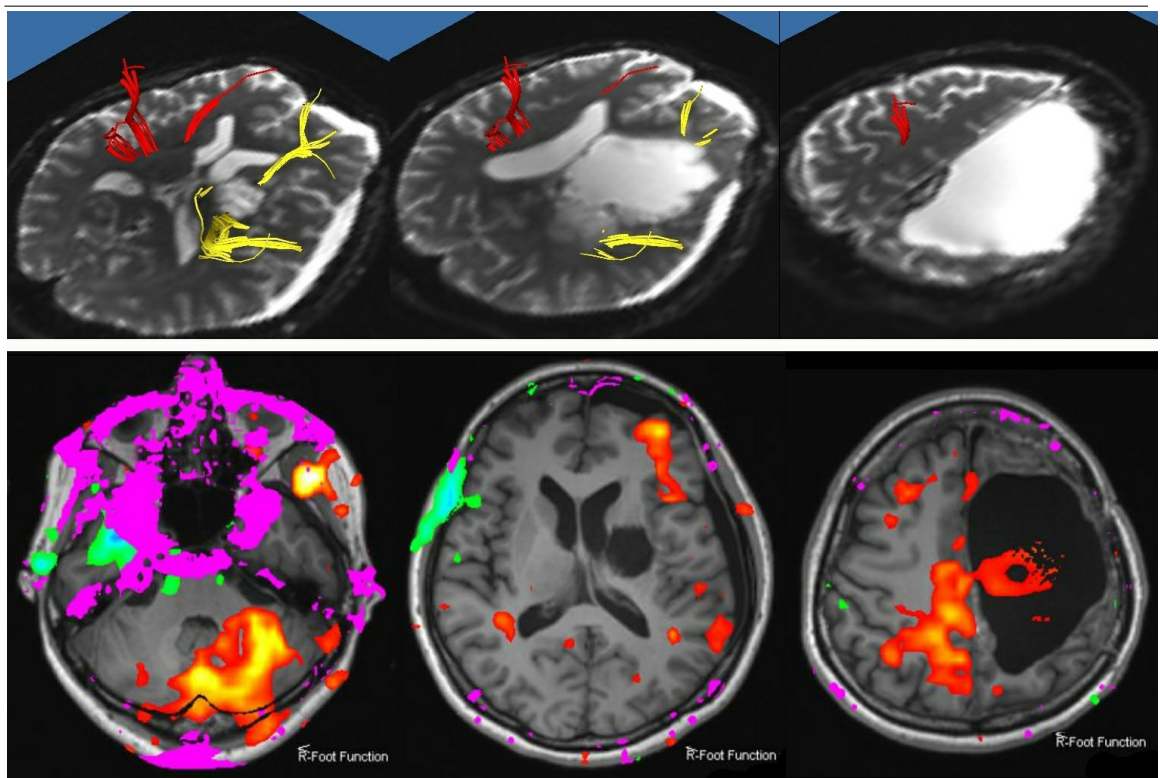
MRI after fifth operation. Tractography in which the seeding point is placed at the cerebral peduncle, showing only fronto-pontine tract and temporo-pontine tract (upper). Functional MRI by the task of right knee extension and flexion showing the hot spot not only in the left cerebellum and right motor area but also in removal cavity.
